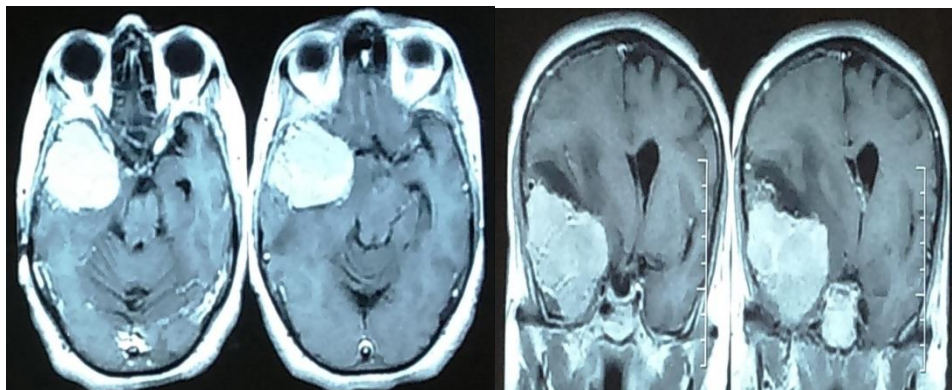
MRI brain with contrast axial cuts (left) and coronal cuts(right) showing right sphenoid ridge meningioma with marked perifocal edema
